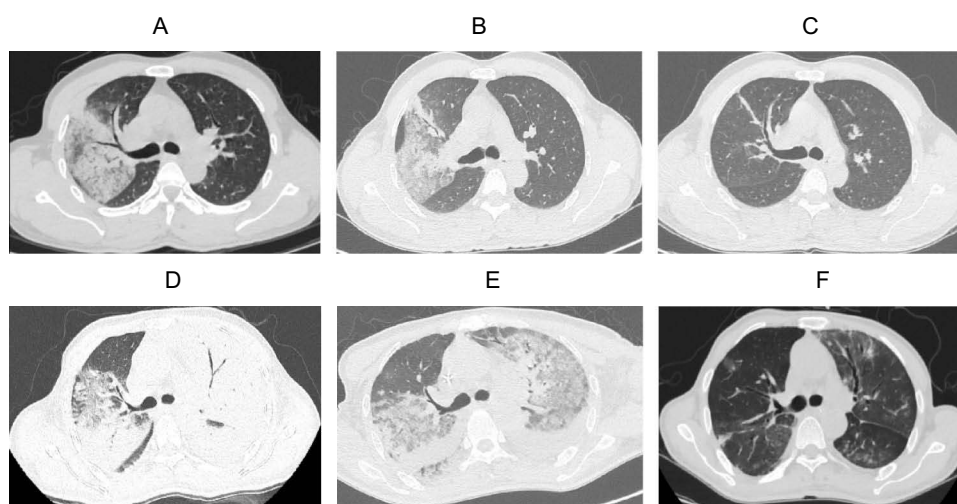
Abbreviation: CT, computed tomography.
